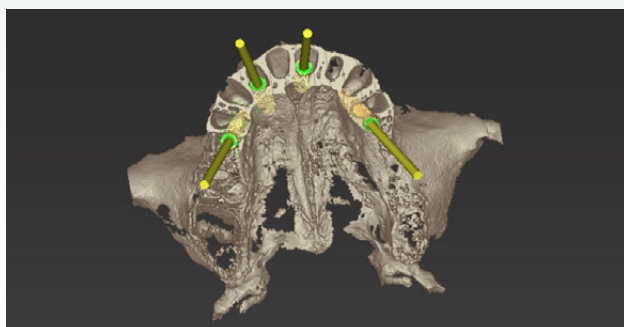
The desired bone reduction was virtually performed on the CBCT DICOM images using the virtual implant planning software.
